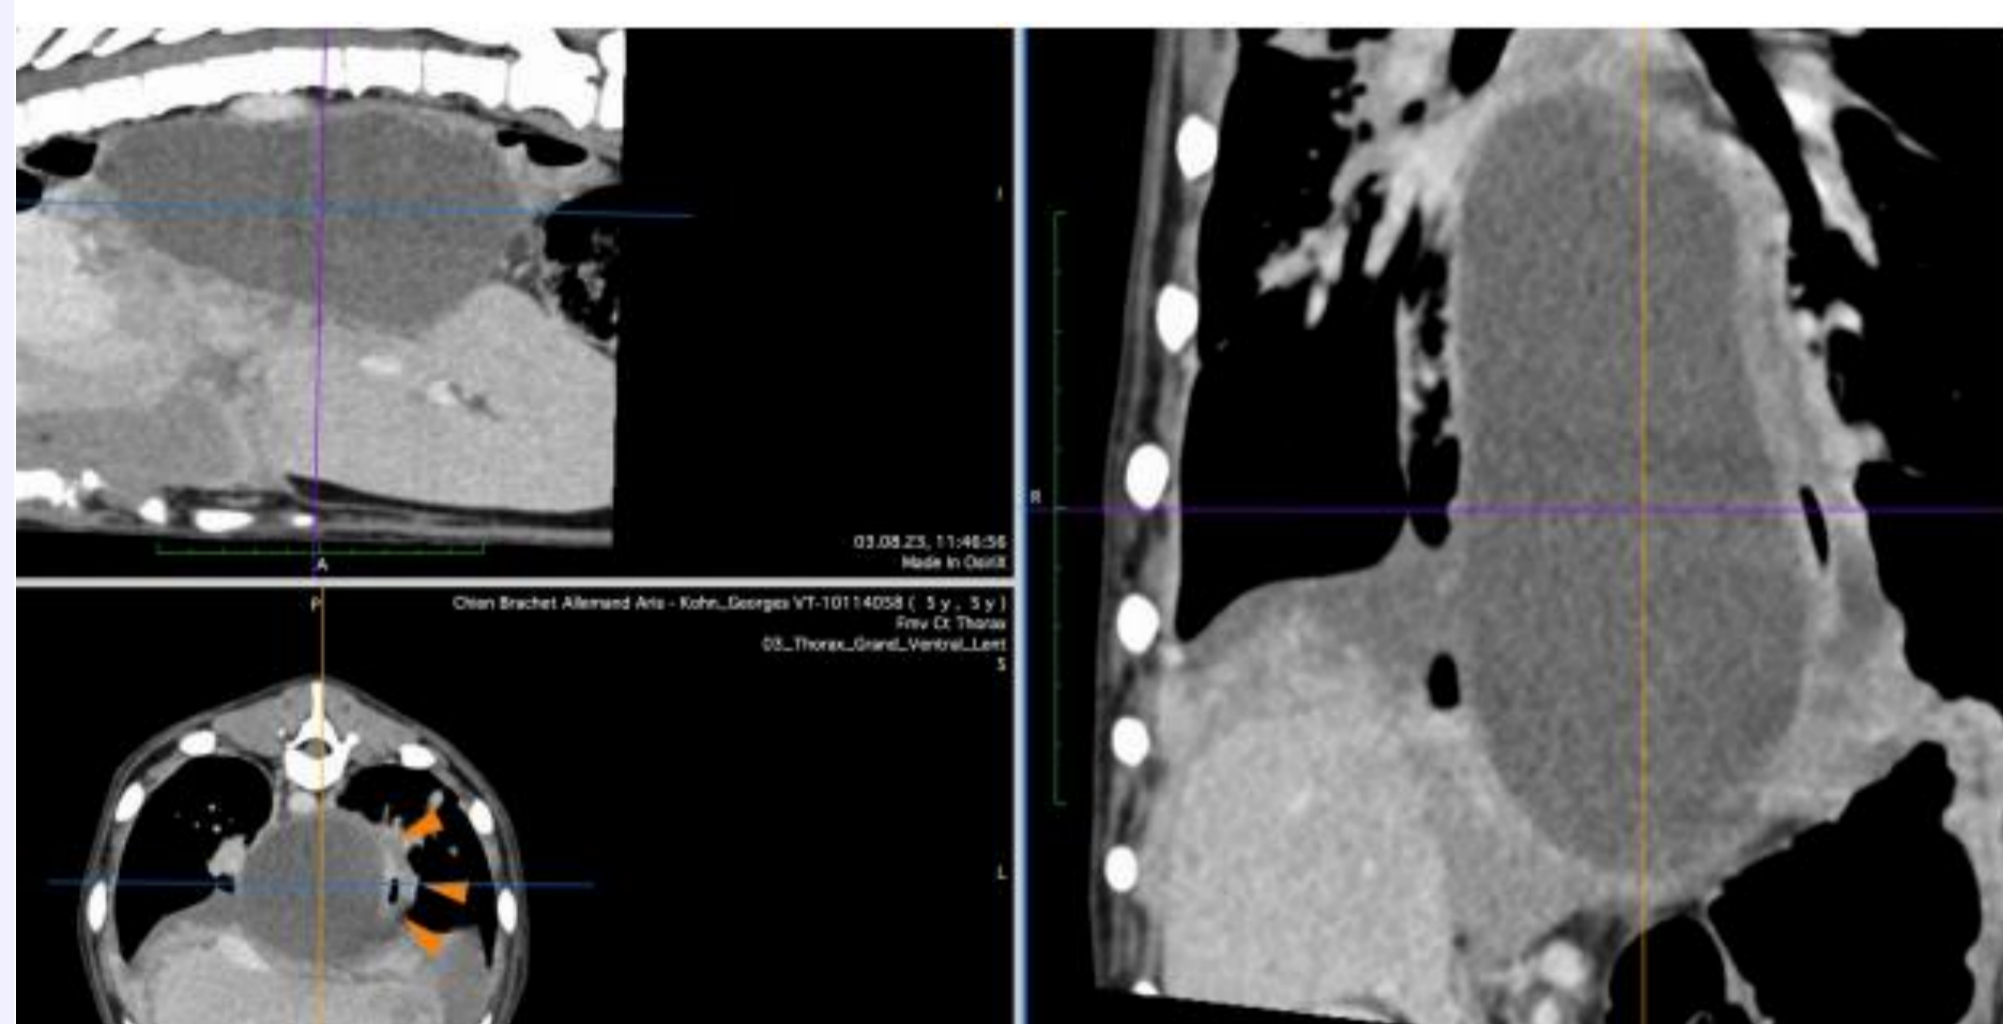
Computed tomography of the thorax.
